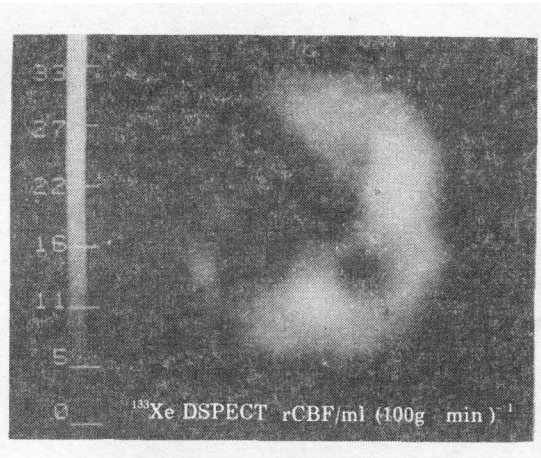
Representative transverse slice of a ^{133}Xe DSPECT study in a patient with post-traumatic coma (pt. n.3)
